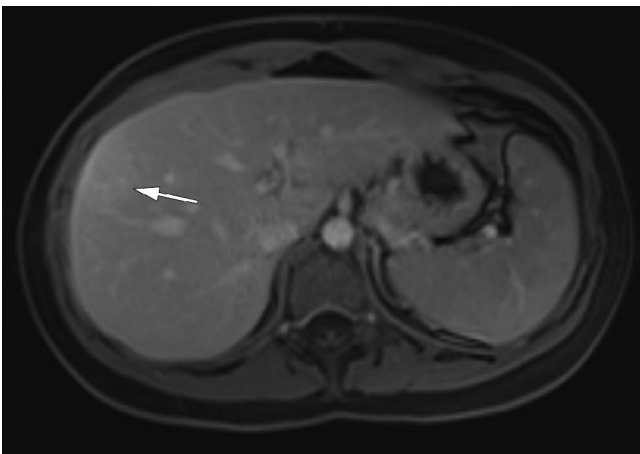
FNH. Annotated. Liver. MRI. T1 weighted. Fat suppression. Contrast enhancement. Delayed phase. Axial plane. On delayed-phase imaging, the mass (arrow) becomes near isointense to background liver, consistent with an FNH.
